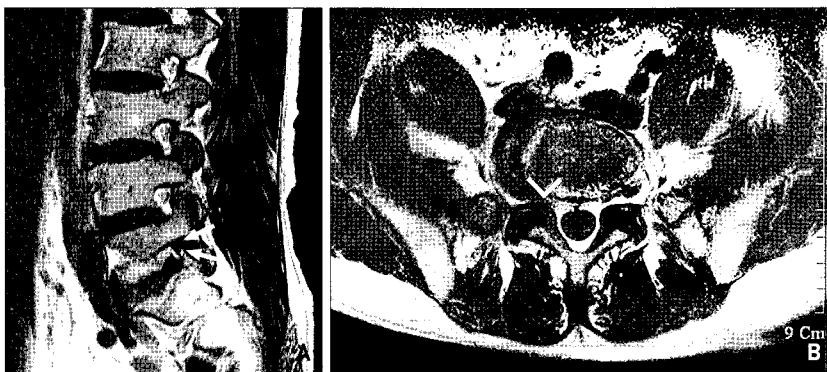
Magnetic resonance image of a 50-year-old male with right L5 radiculopathy. A : Parasagittal T1-weighted image showing foraminal stenosis with circumferential loss of perineural fat signal at the L5S1 neuroforamen (arrows) compared with intense fat signal at the adjacent levels. B : Axial T1-weighted image revealing diminished sized right L5S1 foramen (arrow head).
